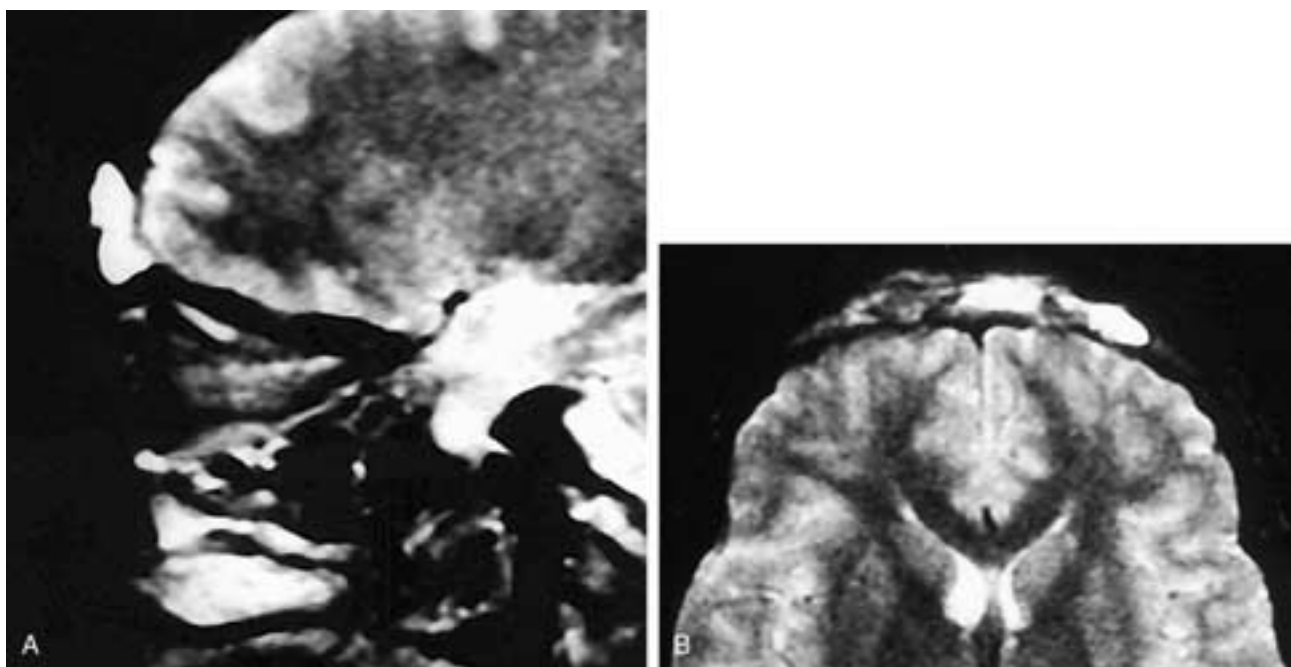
Sagittal (A) and axial (B) T2-weighted MR images on a patient who has had an osteoplastic flap procedure. The right side of the obliterated sinus has a normal fat signal intensity. However, the middle and left regions of the sinus have high signal intensity. This usually indicates the presence of infection, but this patient was asymptomatic. Such high T2-weighted signal intensity may be a normal postoperative MR finding. There is no elevation of the bone flap, and there are no inflammatory changes in the forehead soft tissues.
